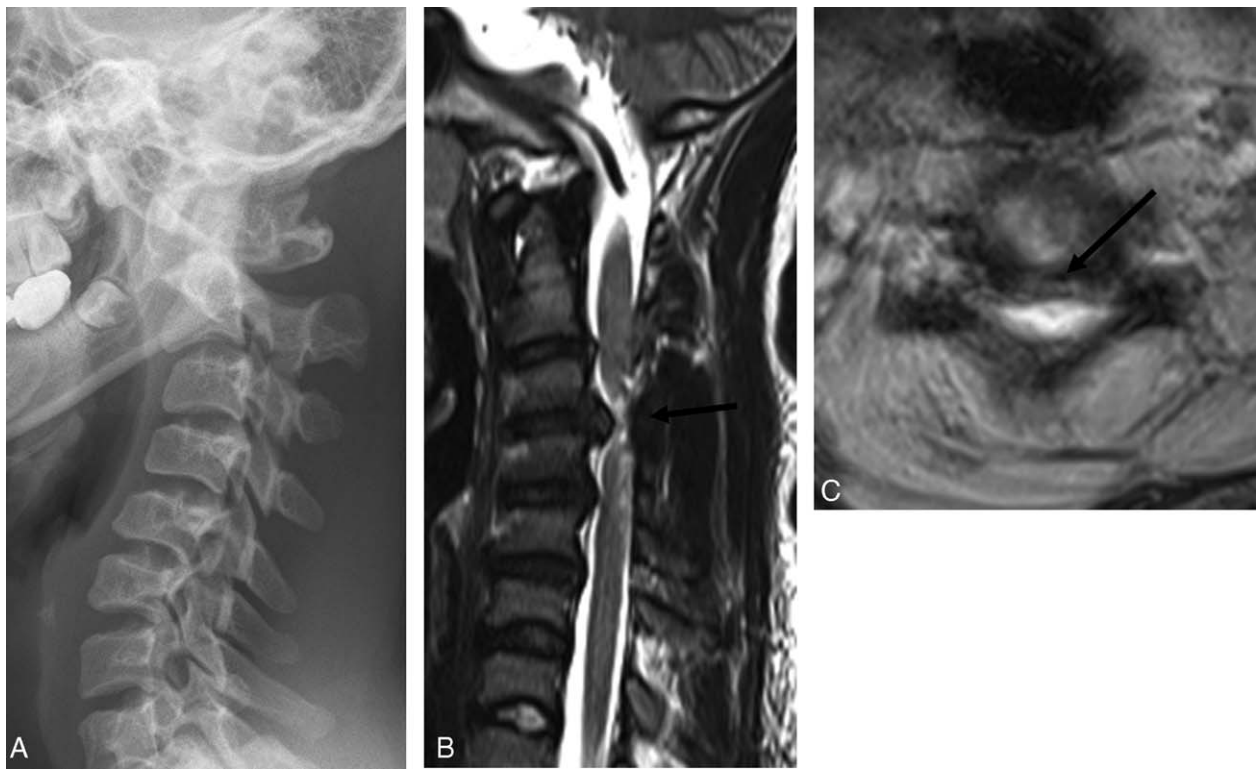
A 19-year-old female patient with athetoid cerebral palsy developed cervical spondylotic myelopathy. On the lateral radiograph, cervical kyphosis and cervical spinal canal stenosis are visible at C3/4 and C4/5 (A). On a sagittal magnetic resonance image (MRI), ventral and dorsal compression of the spinal cord is visible (B). On a horizontal MRI, compression of the C3/4 spinal cord is evident (C).
